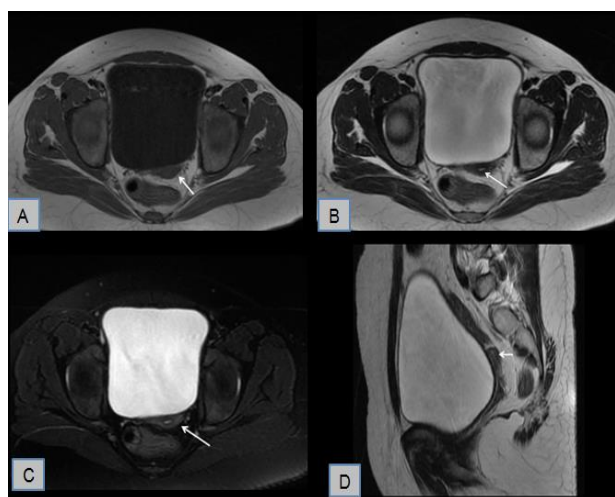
Axial MRI images of pelvis (A) T1W (B) T2W (C) T2 fat saturated and (D) sagittal T2W image showing a atrophic uterus (white arrow) with normal endomyometrial differentiation.
